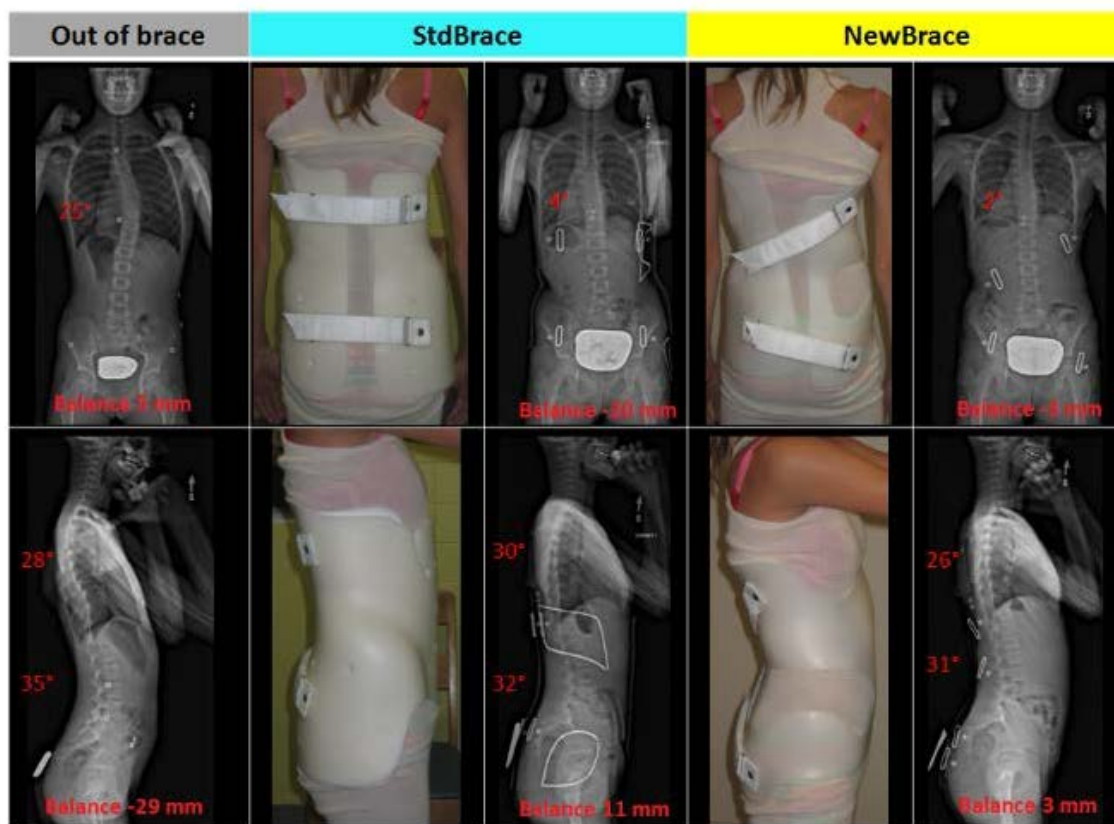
Radiographic results for a typical patient: out of brace (initial curve), with the StdBrace and with the NewBrace, in the postero-anterior and lateral views. Patient's balance is shown in millimeters.
